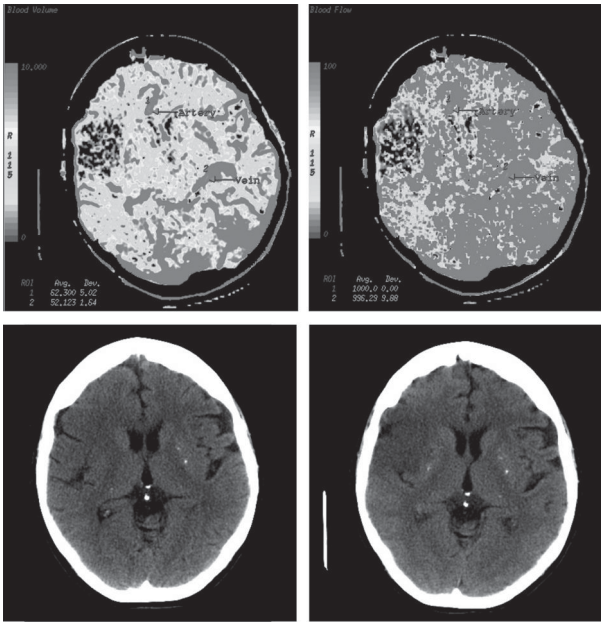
CT perfusion in a patient presenting with a right frontal infarct. On the initial structural CT (bottom left) there are very early ischaemic changes. At this time a CT perfusion scan was performed. The cerebral blood volume and blood flow maps are shown on the upper left and right, respectively. There is a perfusion defect in the right frontal cortex with a matched reduction in cerebral blood volume indicating the tissue is already damaged. On the follow-up CT scan (bottom right), there is an established infarct in this area. © Anthony Pereira.
